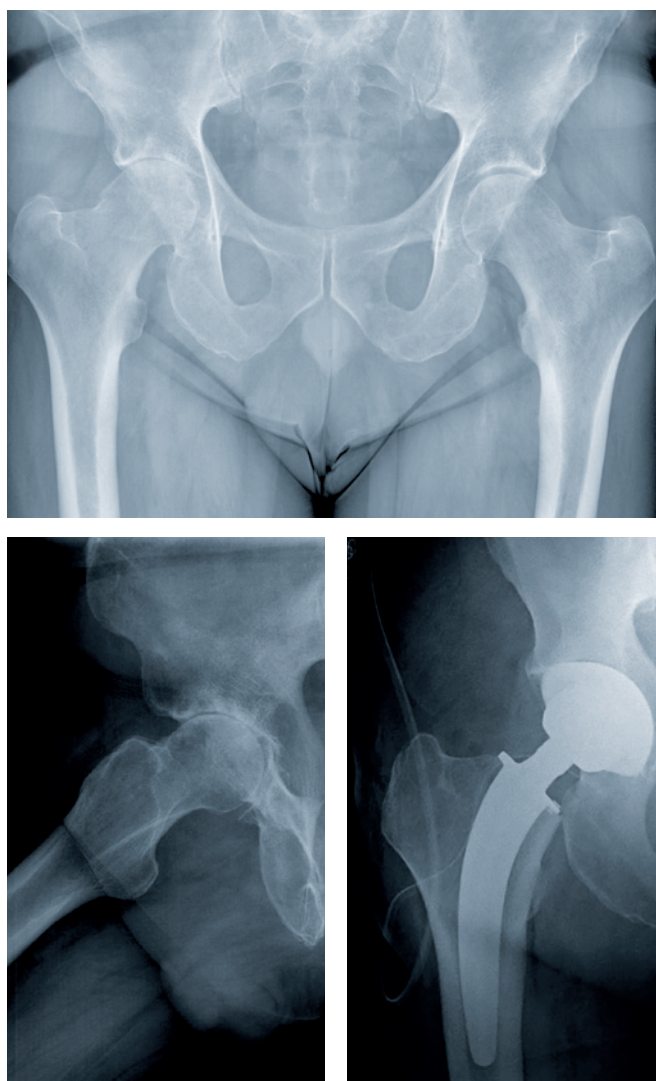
The a–p (Fig. 1) and axial (Fig. 2) x-ray images show signs of right coxarthrosis with wear of the femoral head, osteophytes on the acetabular cup and damage to the acetabular roof. Figure 3 shows a well-positioned acetabular cup inserted up to the lamina, physiological femoral offset and good restoration of Shenton's line.
